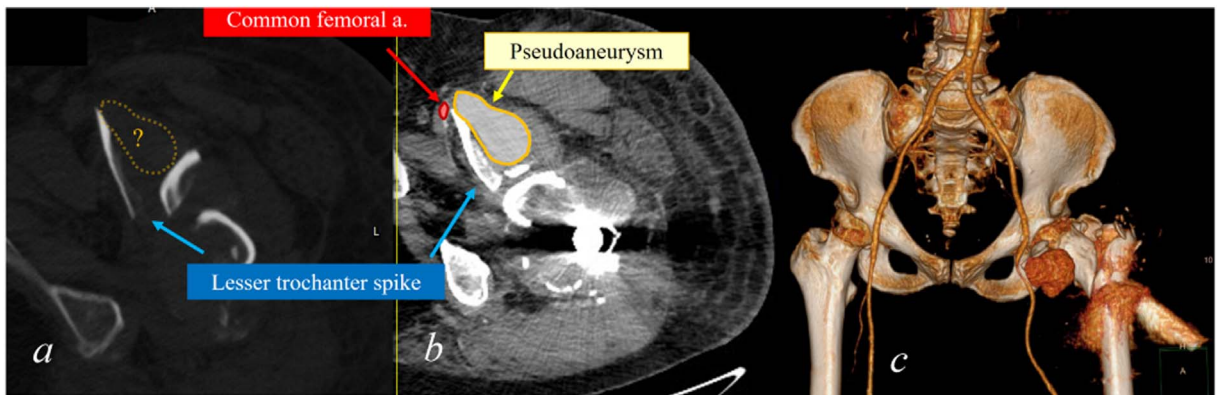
(a) Initial CT scan.
